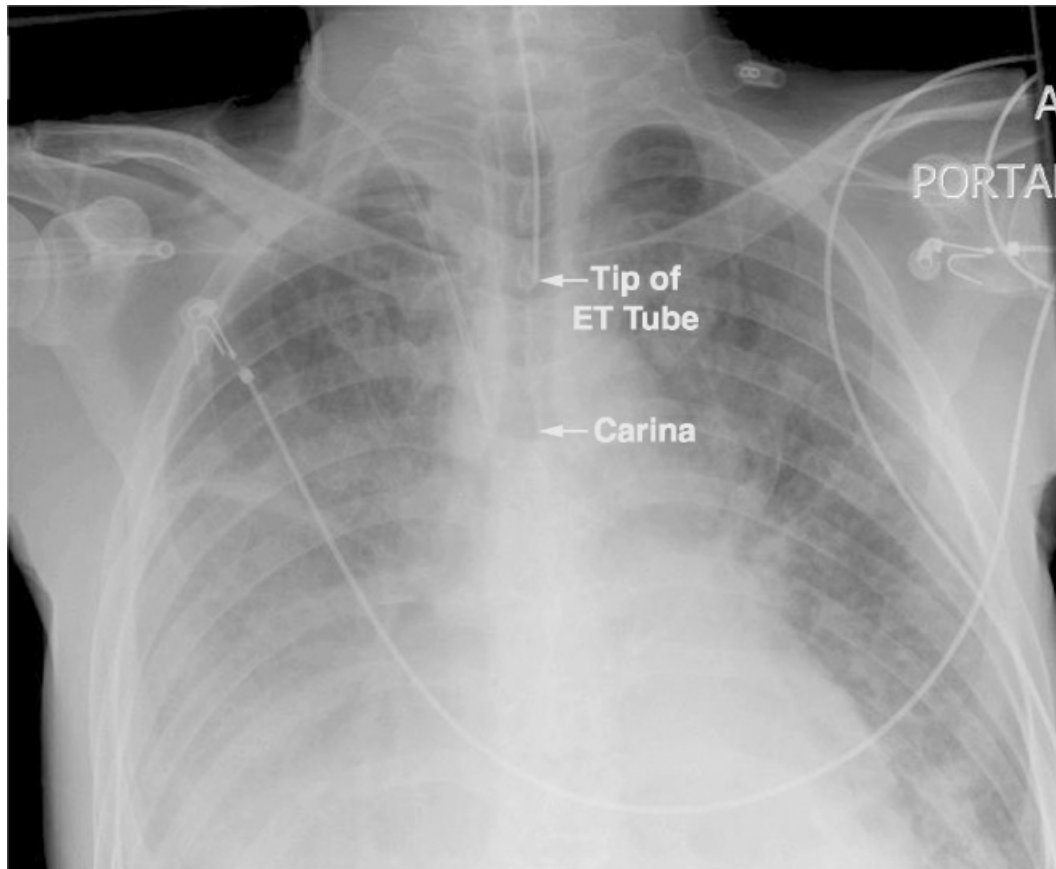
Portable chest x-ray showing proper position of an endotracheal tube, with the tip of the tube located midway between the thoracic inlet and the tracheal bifurcation (carina).
